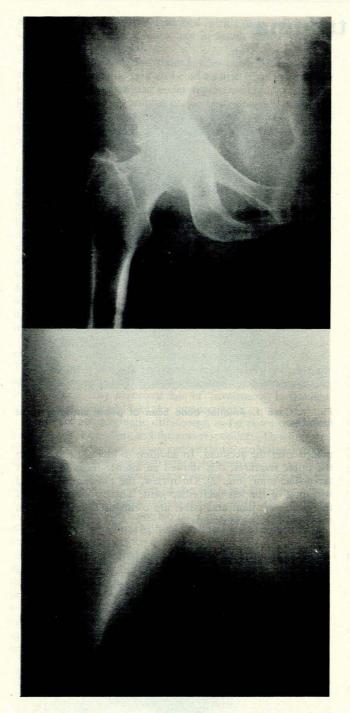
Case 3. Top: radiograph of the right hip; bottom: tomogram of the right hip.
